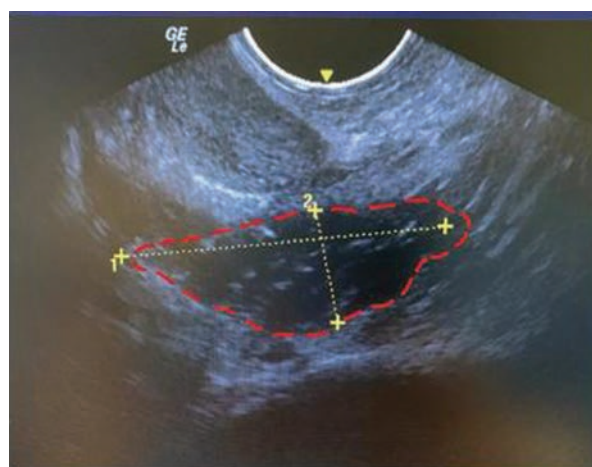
Ultrasound of soft tissues of the gluteal region. A limited accumulation of fluid measuring 4.4×3 cm was detected in the perirectal tissue
